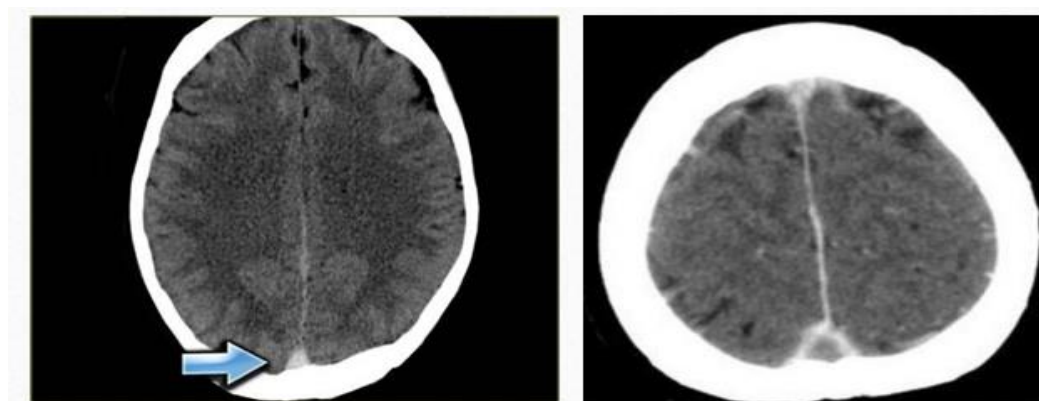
CT Brain showing dense triangle sign (Blue arrow) and empty delta sign (white arrow)
